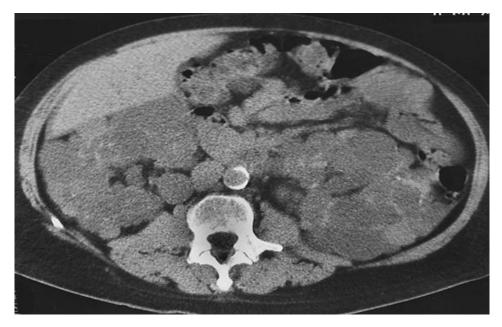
Axial contrast enhanced pelvic CT scan of SCD patient showing Polycystic kidney disease with renal failure, and also shows multiple renal cysts.
